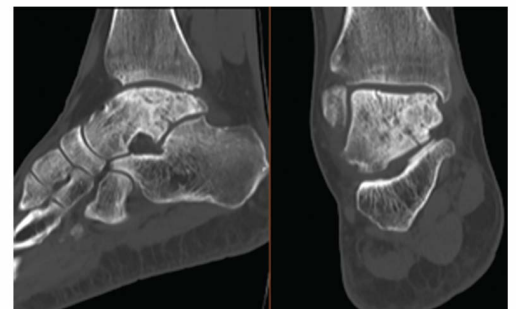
Right Ankle CT July 2023
